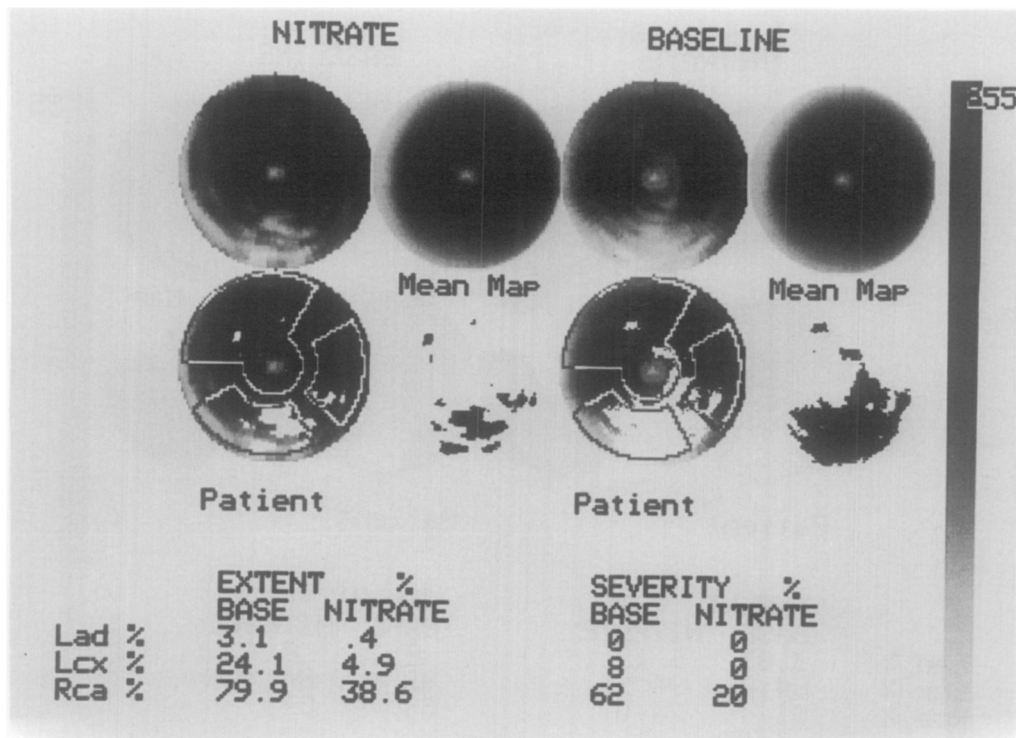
Polar map displays of patient with two-vessel disease, whose prevascularization echocardiogram showed inferior akinesis and inferolateral minimal hypokinesia. Image disposition and abbreviations are same as in Figure 5. On baseline SPECT two territories (left circumflex and right coronary arteries) had significant uptake defect, but one only (right coronary artery) was nonviable according to severity criteria. On nitrate SPECT, left circumflex territory had nonsignificant uptake defect, whereas right coronary artery territory defect was classified as viable according to severity. After two-vessel angioplasty, patient no longer had effort angina and inferior akinesis improved significantly.
